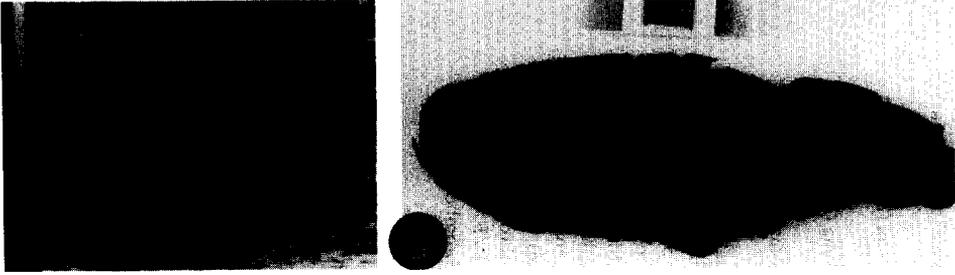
Transverse sonogram (A) at 22 weeks' gestation in case 2 showing gigantic enlargement of the placenta with Swiss cheese appearance related to dilatation of the chorionic and the main villous vessels and myxoid degeneration of the stem villi (B).
